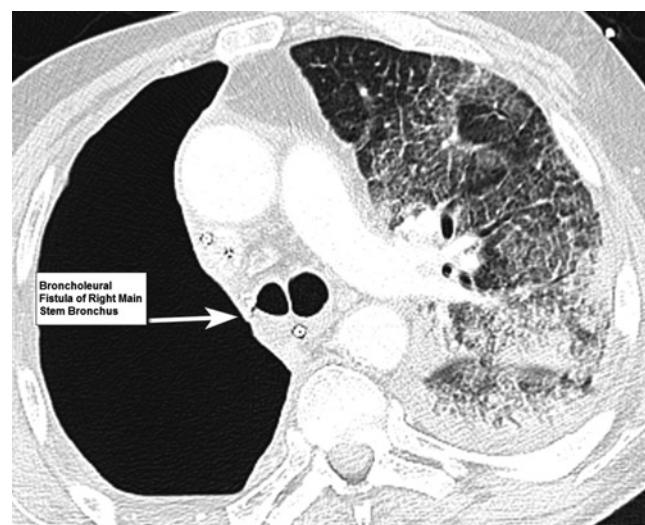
CT image of a bronchopleural fistula in the right main stem bronchus, which developed after pneumonectomy, with accompanying pneumonitis in the contralateral lung.
